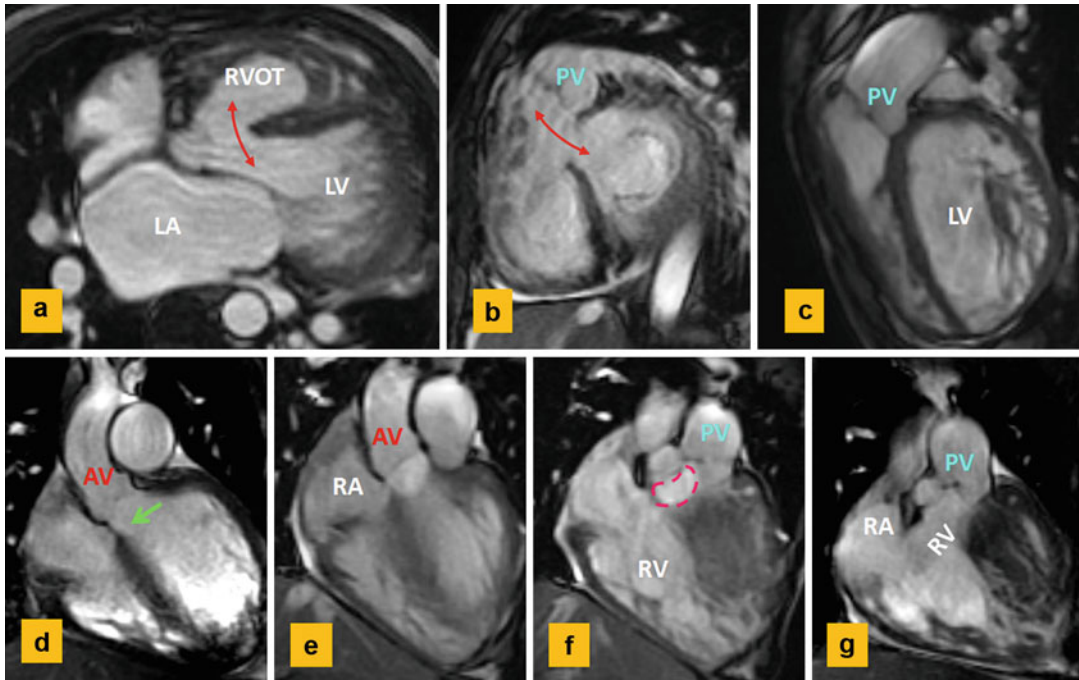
Cine views of MRI in a 54-year-old male with left heart failure and pulmonary hypertension showing a subarterial ventricular septal defect (VSD). (a) Axial view shows the VSD and hypertrophied right ventricle outflow tract (RVOT). (b) Short axis at the level of mitral valve shows large VSD defect (red arrow). (c) Lateral view shows intact pulmonary valve (PV). There subpulmonary
